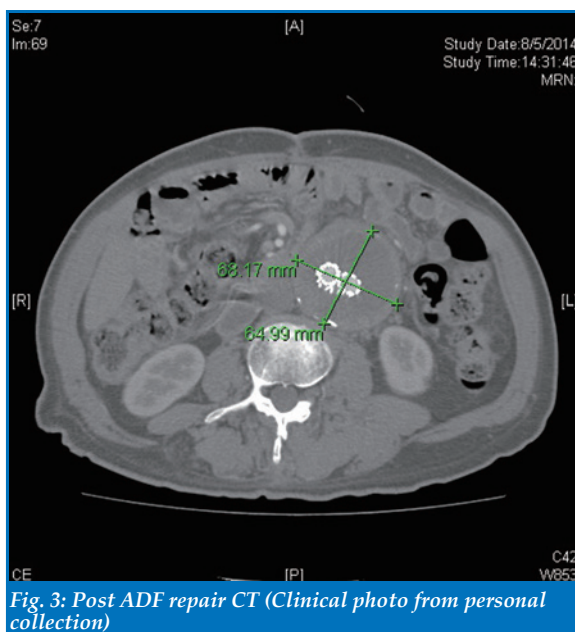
Post ADF repair CT (Clinical photo from personal collection)
